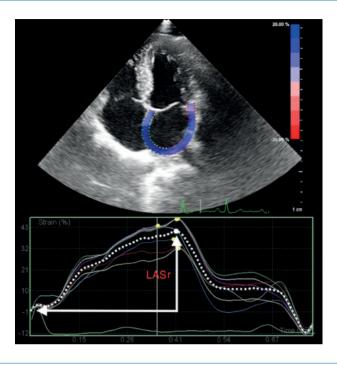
Left atrial deformation parameter measurement by strain echocardiography in patient with acromegaly.
